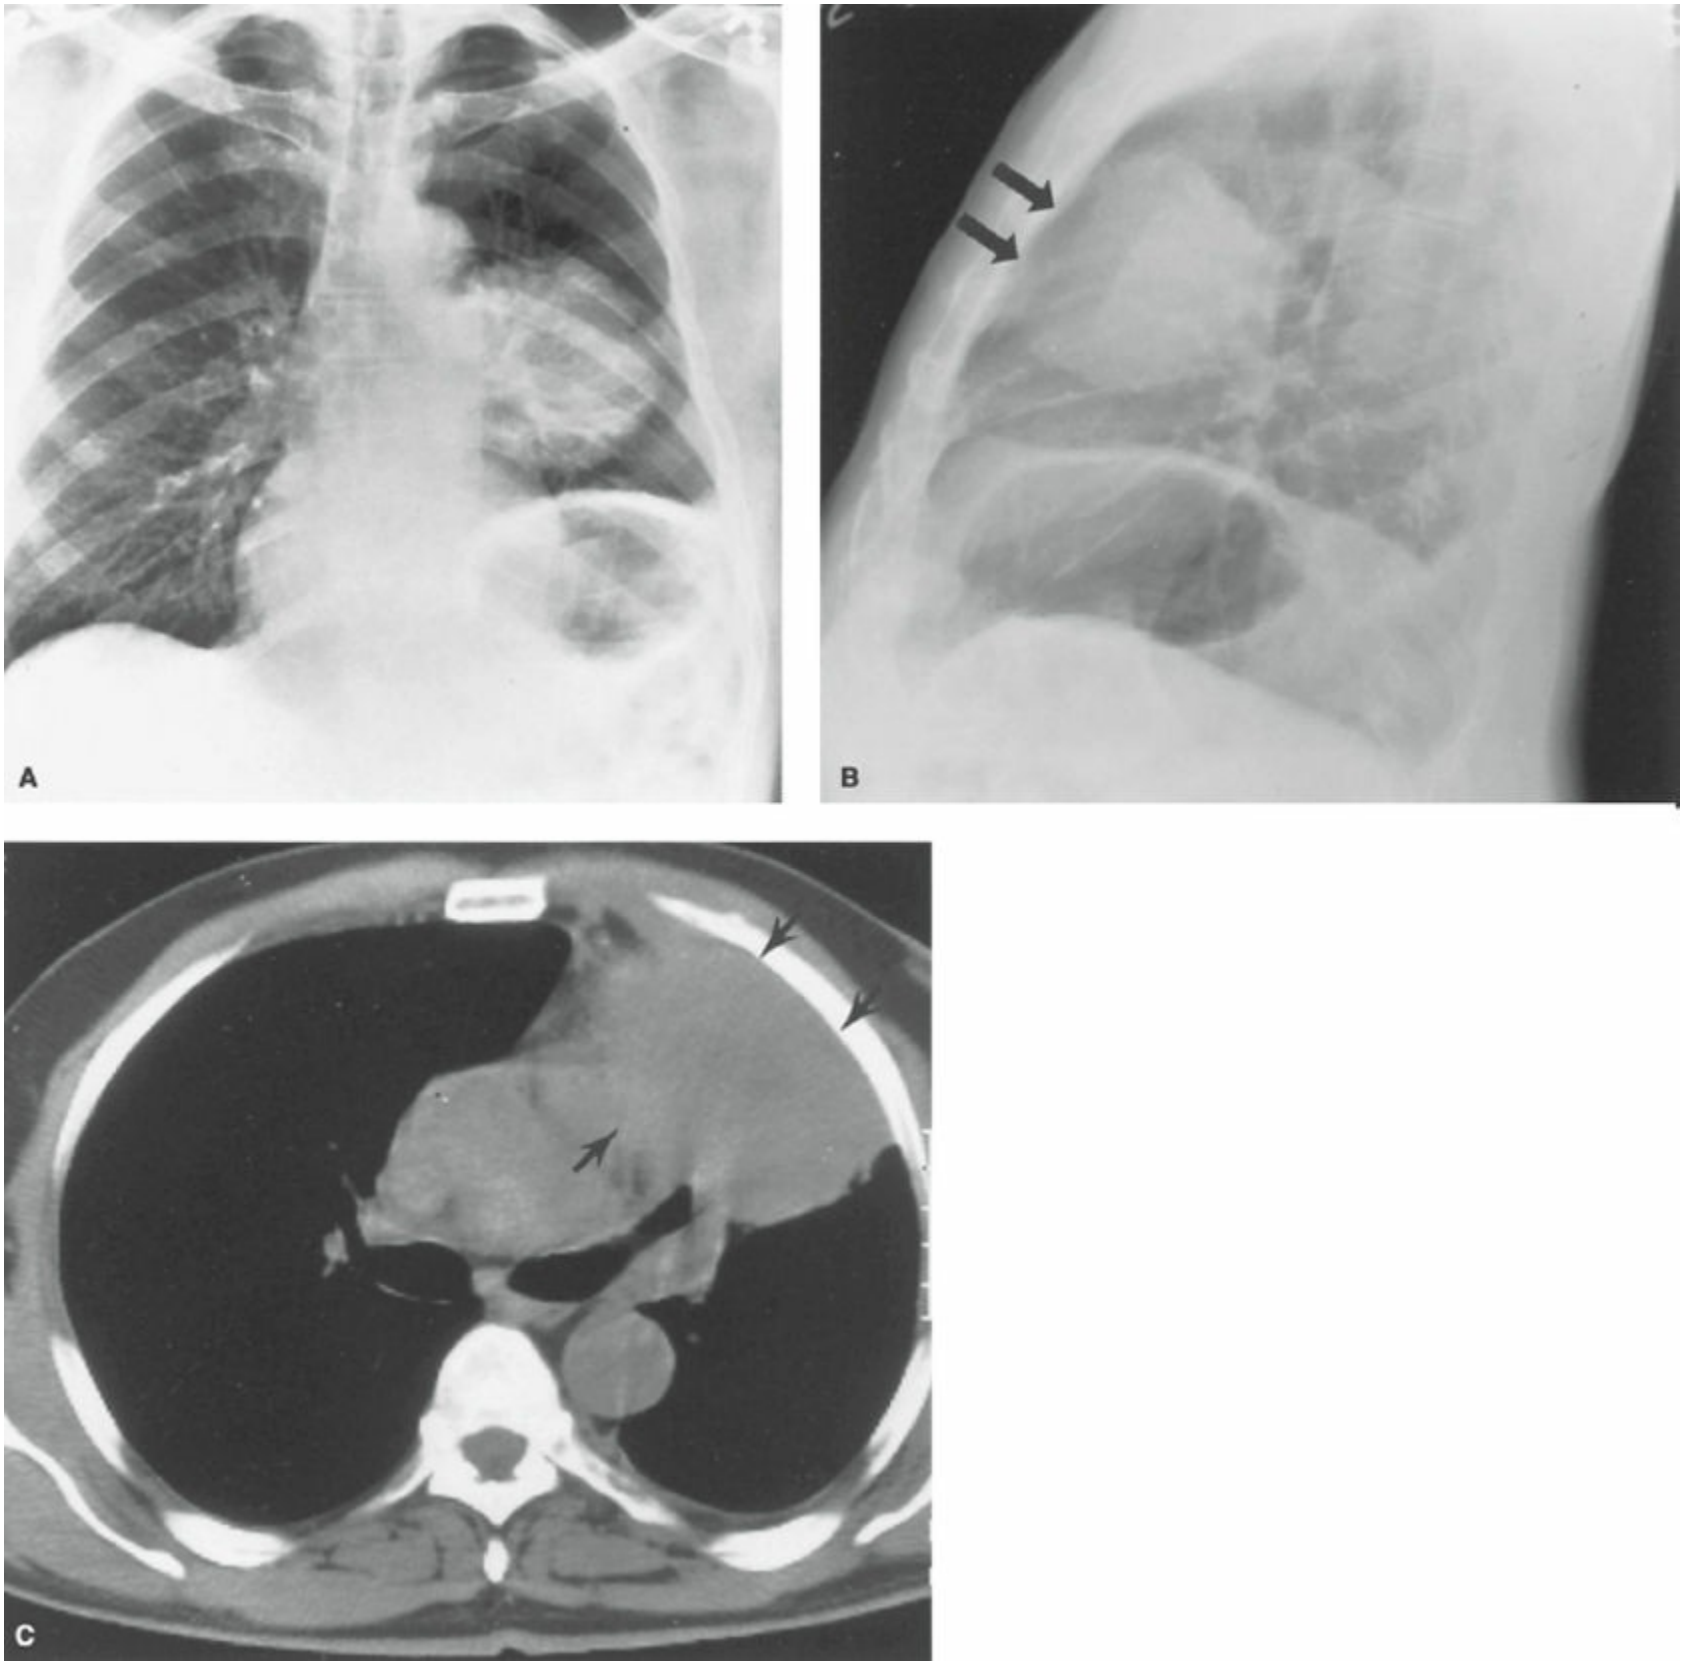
A: Posteroanterior chest radiograph shows an elevated left hemidiaphragm, suggestive of phrenic nerve involvement by the mass. B: Lateral chest radiograph shows extension of the mass into the anterior chest wall (*arrows*). C: Computed tomography suggests both pericardial and chest wall involvement (*arrows*). At thoracotomy, the chest wall, phrenic nerve, and pericardium were found to be involved. All were resected en bloc with the tumor.
